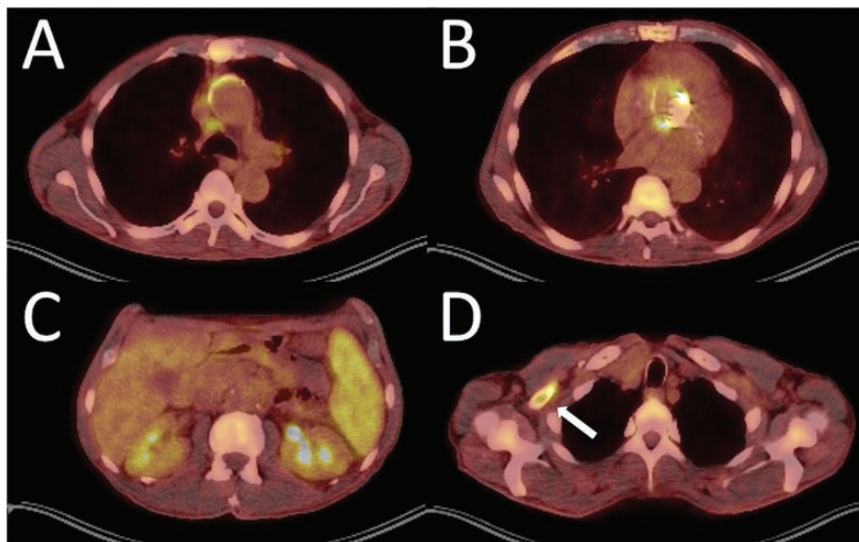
Images obtained using a ^{18}F fluorodeoxyglucose-positron emission tomography/computed tomography scan showing abnormal hypermetabolic activity in the aortic arch (A), aortic root/valve prosthesis (B), spleen (C), and axillary region of the right subclavian artery (D).
